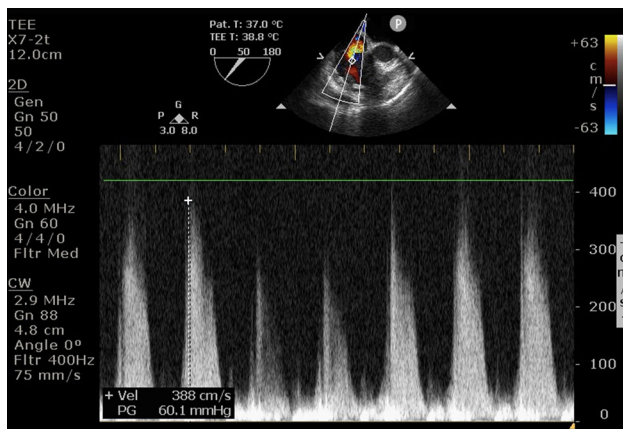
Doppler flow showing severe pulmonary hypertension with a peak gradient of 60 mm Hg across the tricuspid valve
